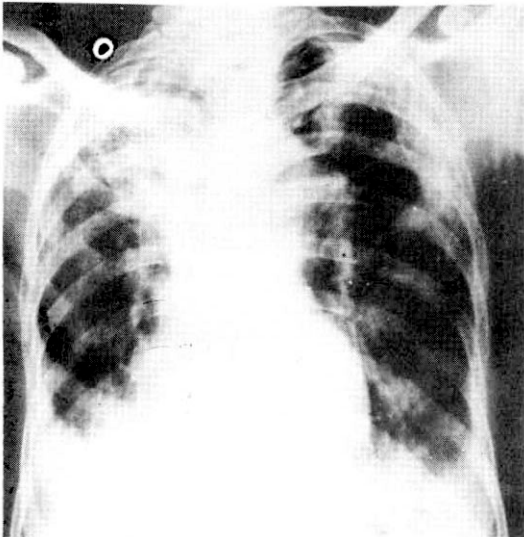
Chest X-ray at the time of admission. Streaky and patchy densities with volume loss are seen on right upper lung with both lower lung infiltration.
